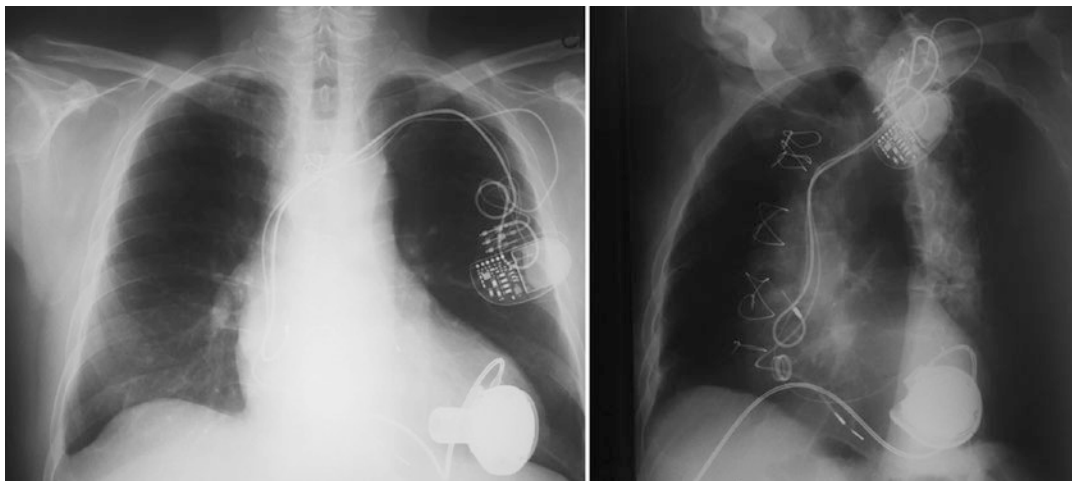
Lack of CRT response in a patient with apparent anatomic optimal LV lead position (PA and LAO chest X-rays). The patient required a left ventricular assist device for refractory HF as a bridge to transplant
